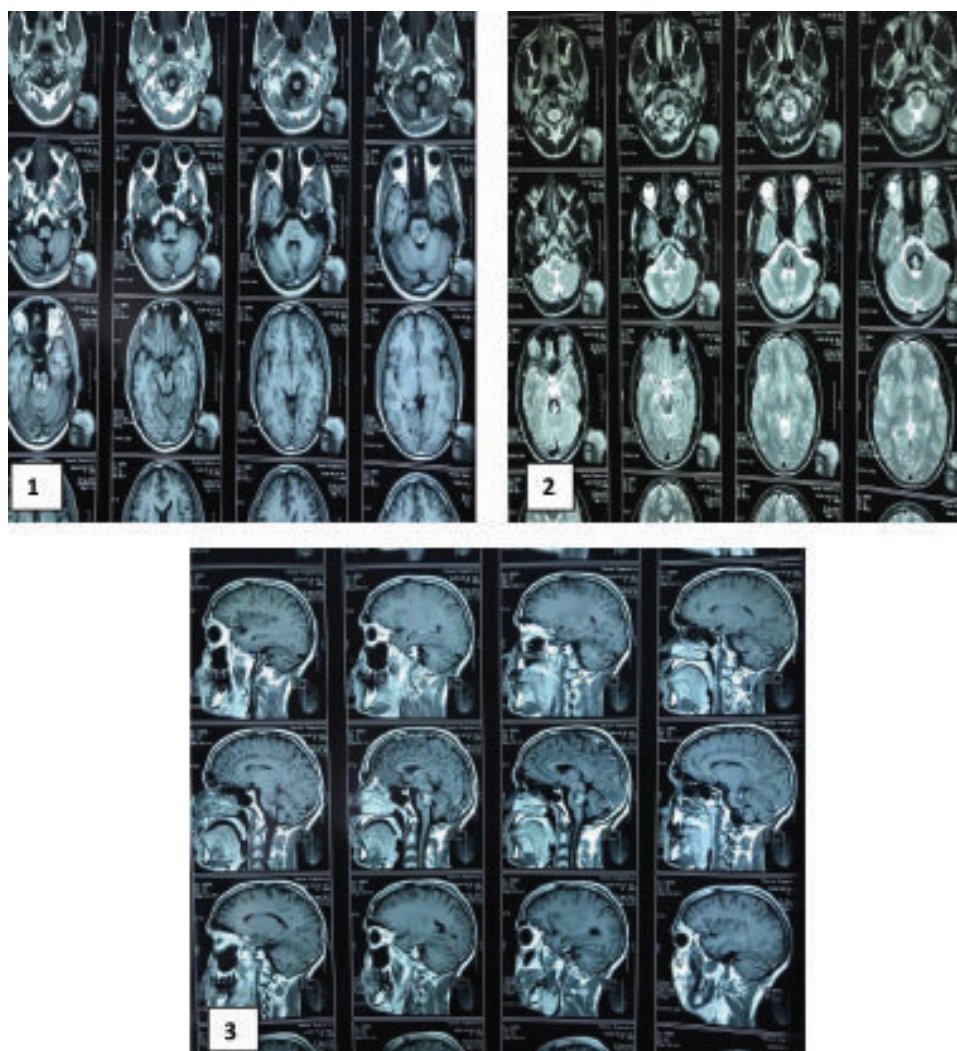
Preoperative MRI of the brain showing an intrinsic lesion in the posterior aspect of the pons.
